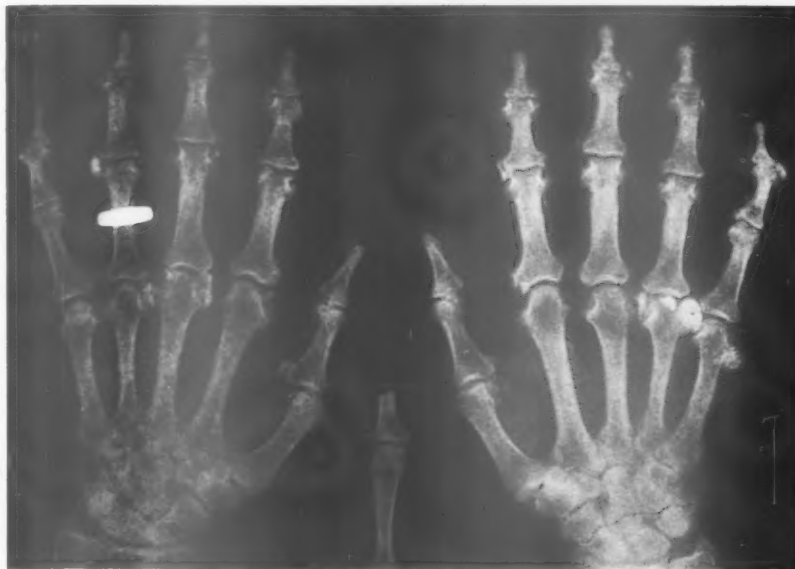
(b).—Case 2, radiographs showing more severe changes.
